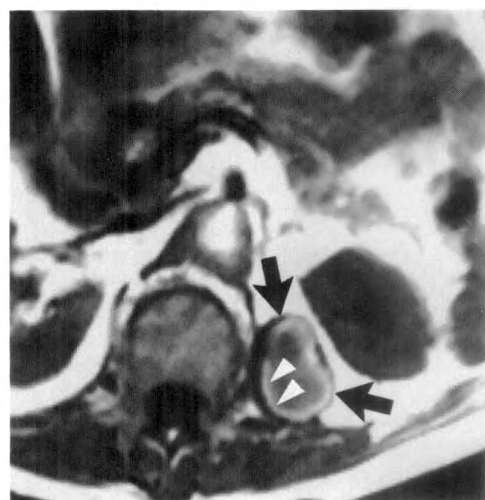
SE 310/20/12 MR image of left psoas hematoma after 7 weeks (same patient as in Fig. 1) shows bright ring (arrowheads) immediately central to dark rim (arrows).
